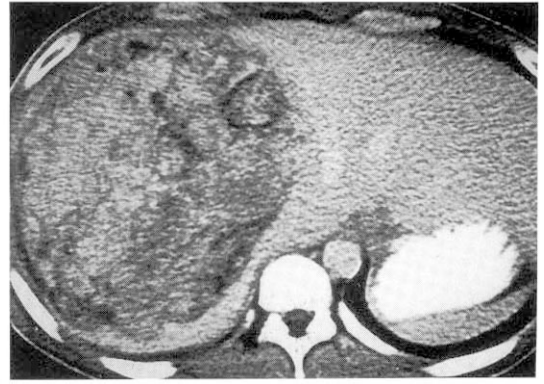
CT: An enhanced round mass with multiple irregular fat dense areas and sharply defined margin.
